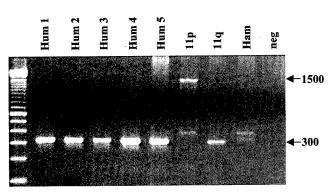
Deletion of the original PSMA-like promoter, exon I and part of intron I. PCR analysis was performed using primers based outside the region predicted to be deleted in the PSMA-like gene. Amplification of the predicted 300 bp band if a deletion had in fact occurred is seen in all five human DNAs (hum I – 5) and DNA from the IIq human-hamster hybrid (IIq). Amplification of the I,500 bp band in the homologous region of the PSMA gene is generated from the IIp hybrid (IIp). "Ham" indicates the parental hamster DNA of the hybrids.
